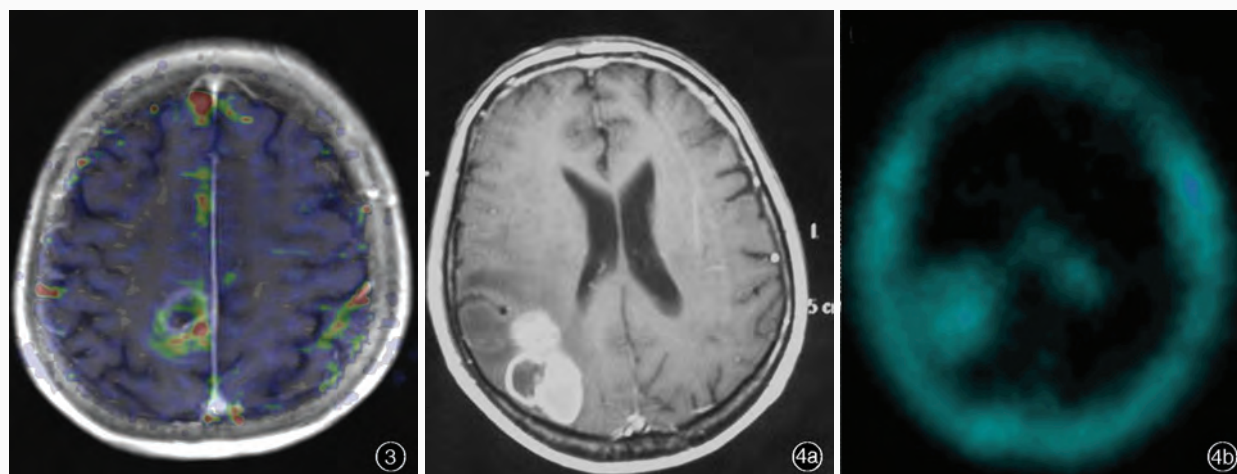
rCBV map superimposed on T₁WI with gadolinium enhanced revealing the tumor's 'hot spot' in which a stereotactic biopsy should be performed Figure 4 A case of glioblastoma exhibits profound tracer uptake in ^{99m}Tc - Tetrofosmin brain SPECT. Axial enhanced T₁WI (Panel 4a). SPECT (Panel 4b)
